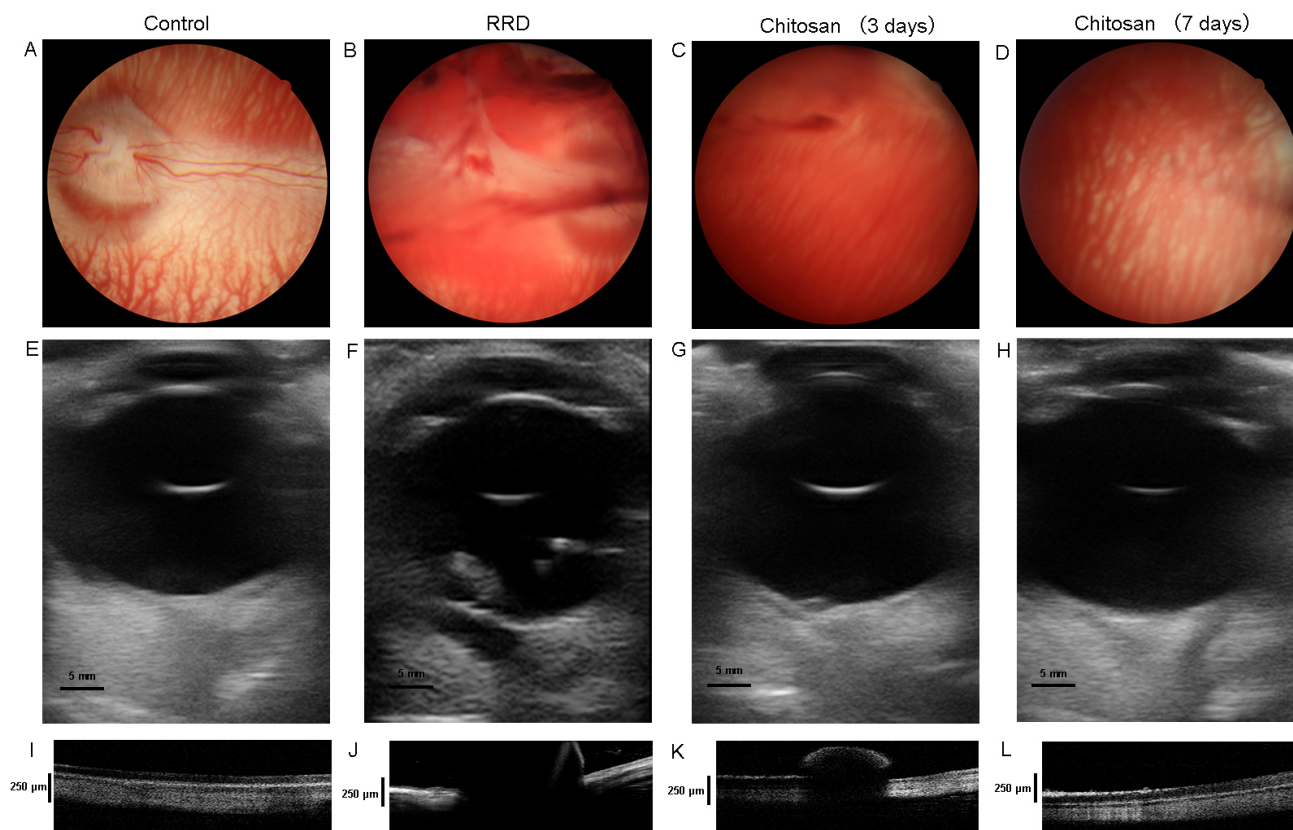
Fundus examination (A–D), B-mode ultrasound (E–H) and OCT findings (I–L) (n = 6). Chitosan (day 3): chitosan group on day 3 after operation, Chitosan (day 7): chitosan group on day 7 after operation.
